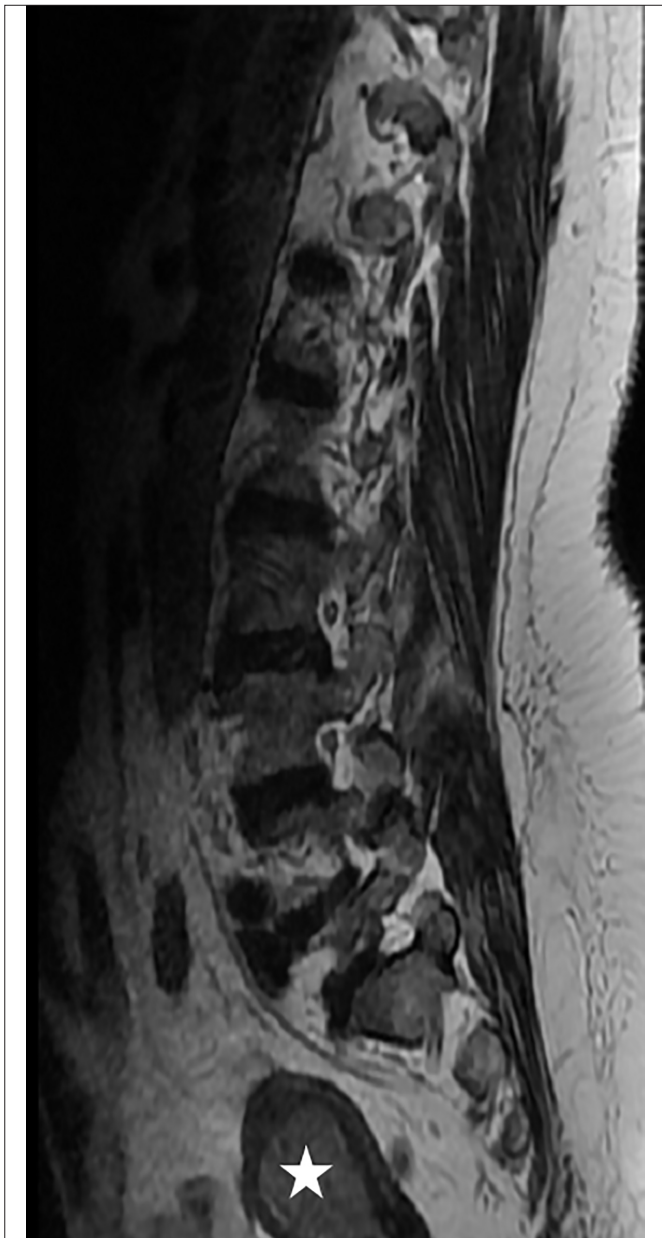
Postmenopausal endometrial hyperplasia (star) in the T2-weighted sagittal image.
